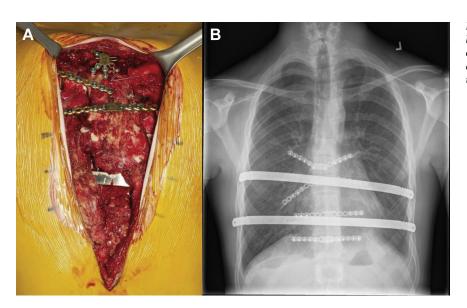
Titanium plating and sternal support bars are used and shown in (A) intraoperative photographs and (B) postoperative chest roentgenogram after hybrid reconstruction.
